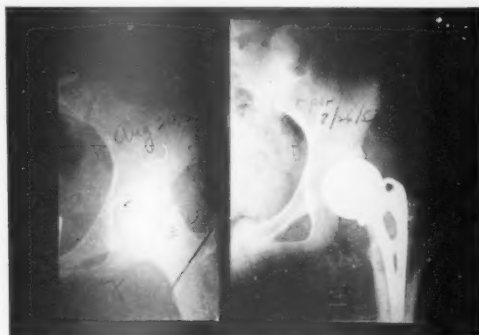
Roentgenogram of aseptic necrosis of femur in 13-year-old girl; result of trauma; hip painful, range of motion 40 per cent of normal; prosthesis; patient now 5½ years postoperatively.
